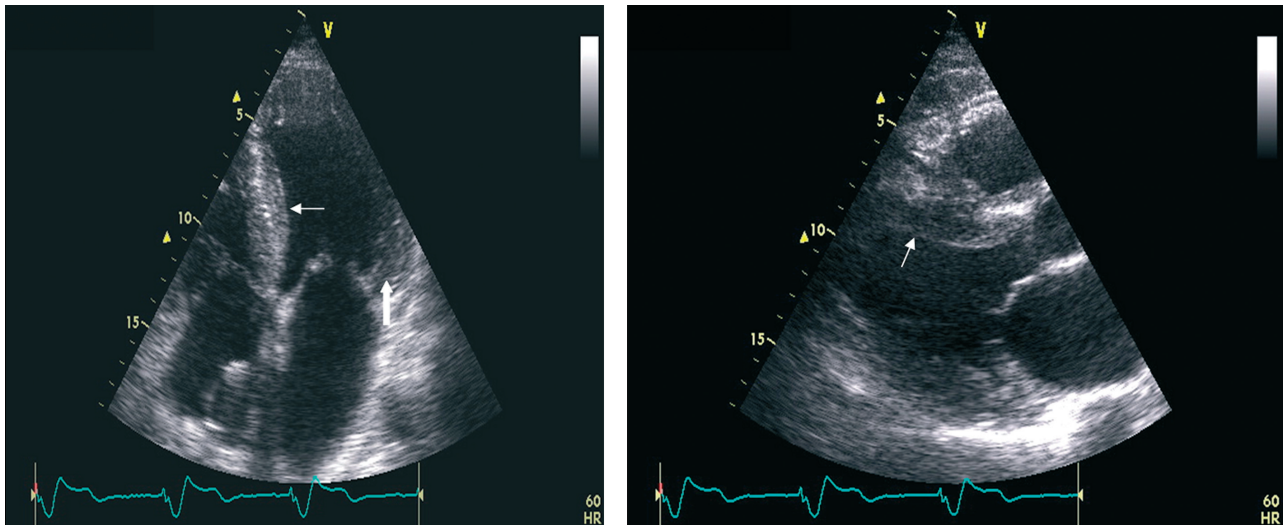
Echocardiography showing profound septal hypertrophy (small arrow) and left ventricular hypertrophy (broad arrow). Apical 4-chamber view (left), parasternal long axis (right).
